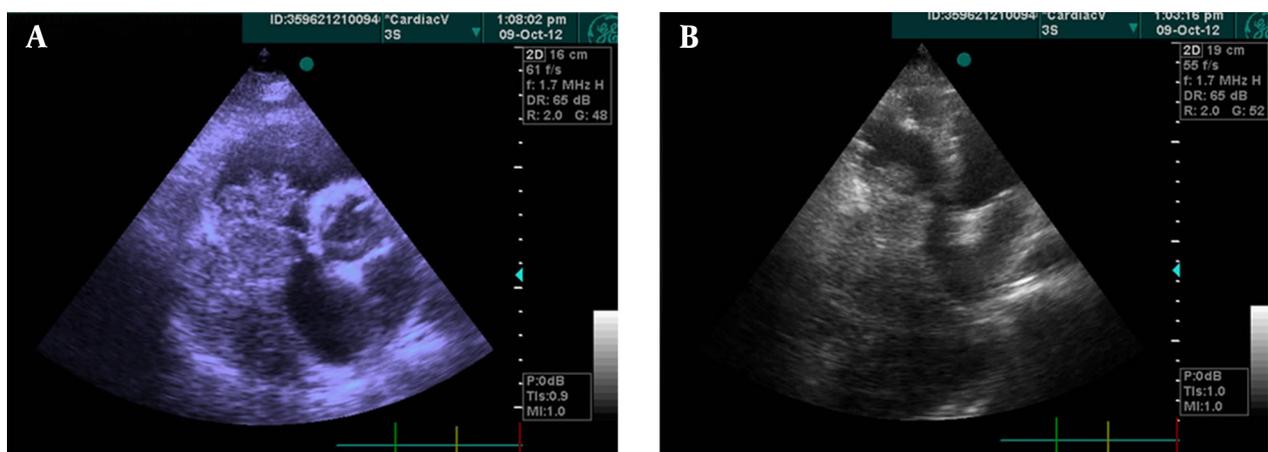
A, Transthoracic Short-Axis View Shows Large and Multilobulated Mass Extend From RA to RV and Destroyed Tricuspid Valve; B, Transthoracic Long Axis View Shows Pericardial Effusion and Thick Pericardium With Mass
